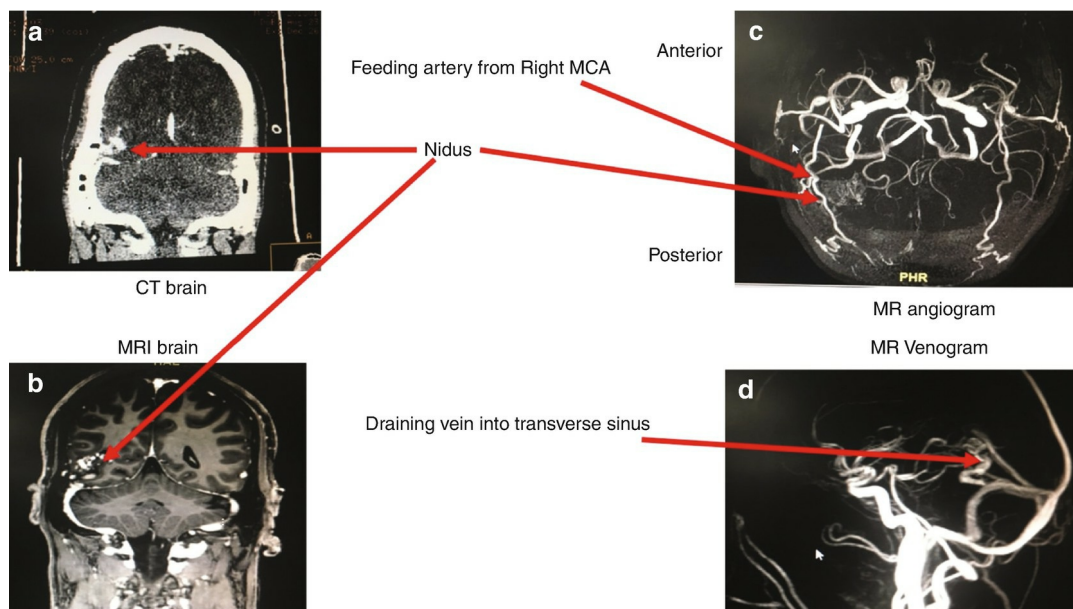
Imaging modalities. (a) CT brain, (b) MRI brain, (c) MR angiogram, (d) MR venogram. CT computed tomography, MRI magnetic resonance imaging, MR magnetic resonance
